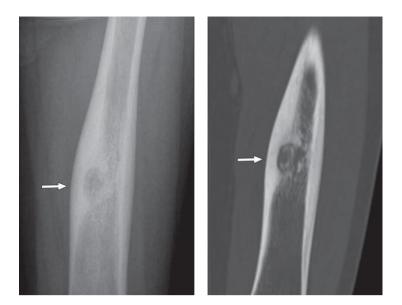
AP radiograph and coronal CT shows lucent nidus (*arrows*), with ringlike, calcifications noted on inner aspect of femoral cortex (3).
